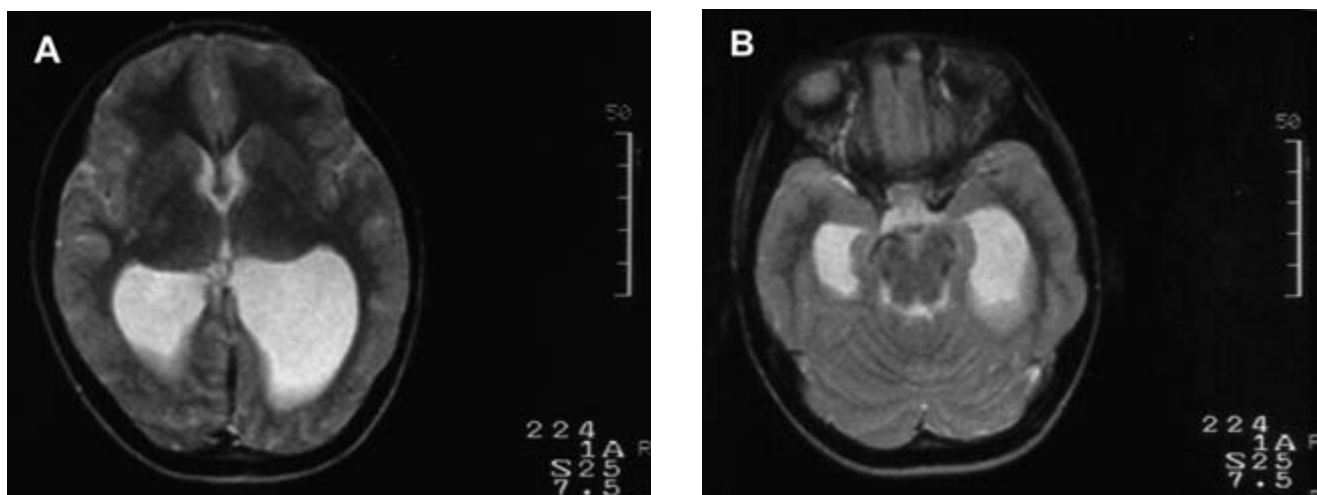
Patient no. 6. Axial T2-weighted image. (A) Colpocephaly. (B) dilated temporal horns of the lateral ventricles.
